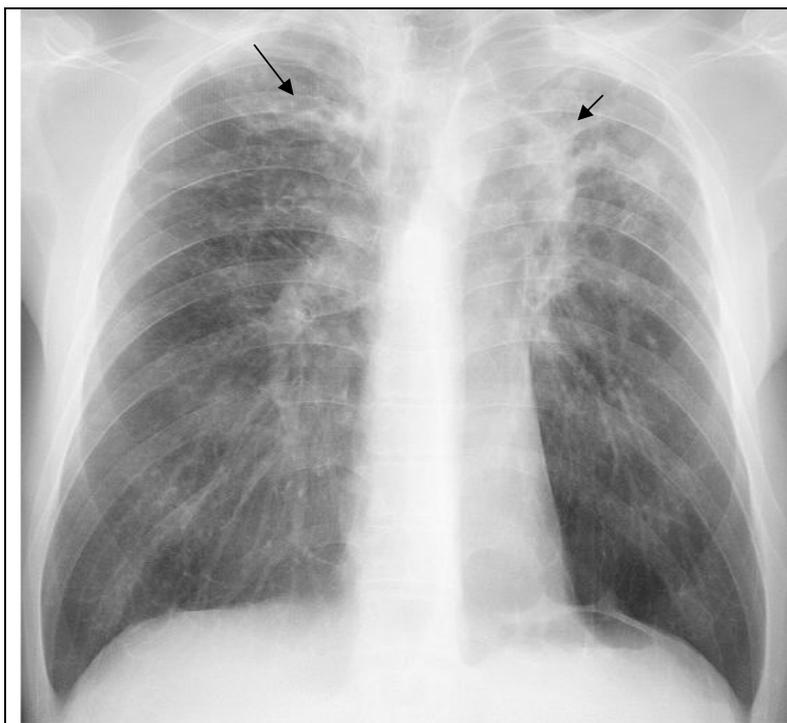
The frontal chest radiograph. In the upper departments of both lungs the limited non-homogeneous shadows with distinct contours (arrow). Hilums of both lungs shift upwards. The tuberculosis of both lungs with fibrosis.
